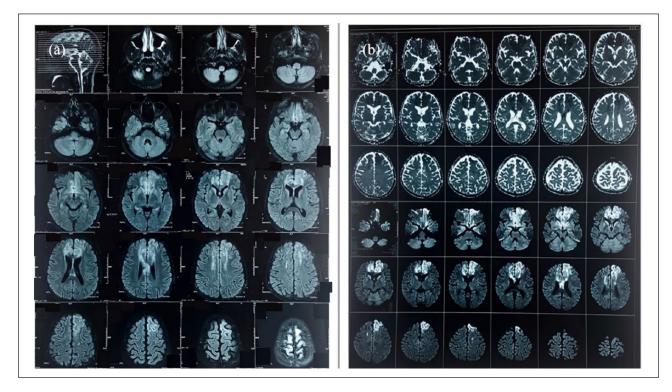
(a) MRI FLAIR axial images showing cortical and subcortical white matter signal changes in both frontal lobes compatible with bilateral frontal lobe acute infarctions in the anterior cerebral artery territory. (b) Restriction in DWI in both frontal lobes compatible with bilateral frontal lobe acute infarctions.
